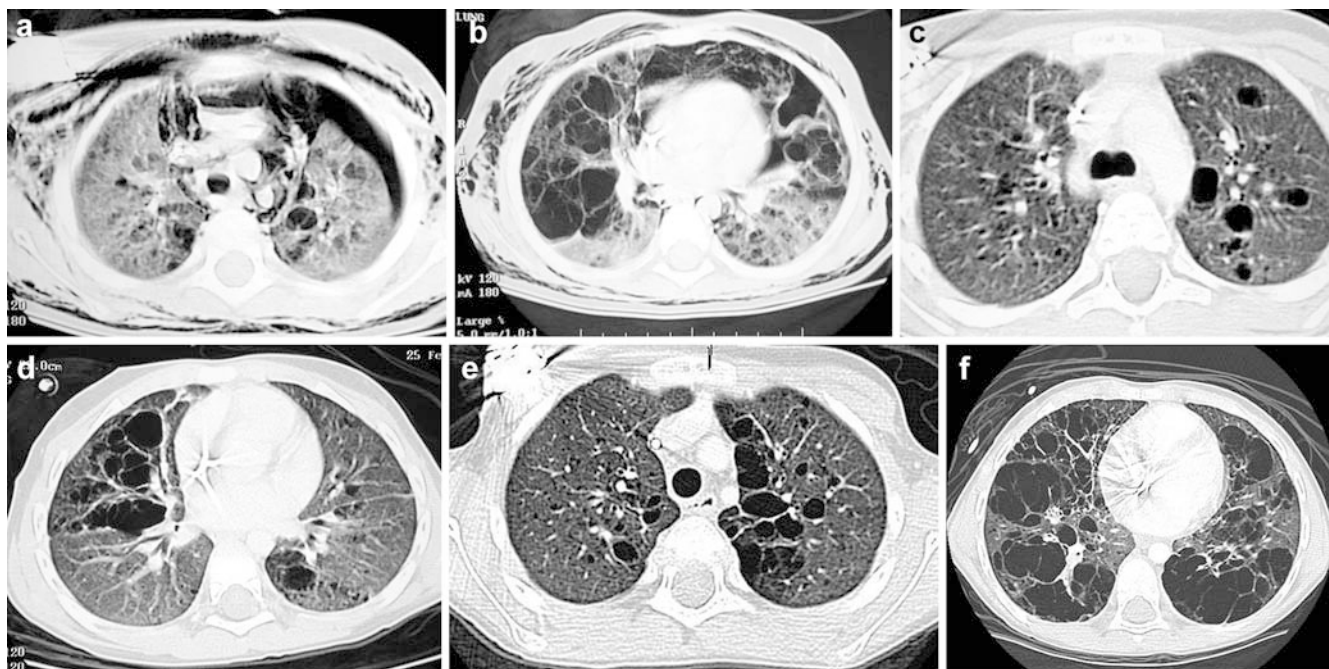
Lung involvement by LCH in the same 3-year-old boy as in Fig. 3. a, b Chest CT performed as an emergency depicts multiple air-filled cysts and reticulonodular changes associated with acute spontaneous left anterolateral pneumothorax, pneumomediastinum and subcutaneous emphysema. c, d HRCT 20 months later. There is persisting lung emphysema with fibrosis characterising the chronic destruction of pulmonary parenchyma with regression of the acute involvement. e, f Follow-up by chest CT after a further 40 months shows slow, but irreversible progression of the lung emphysema without any acute complications
